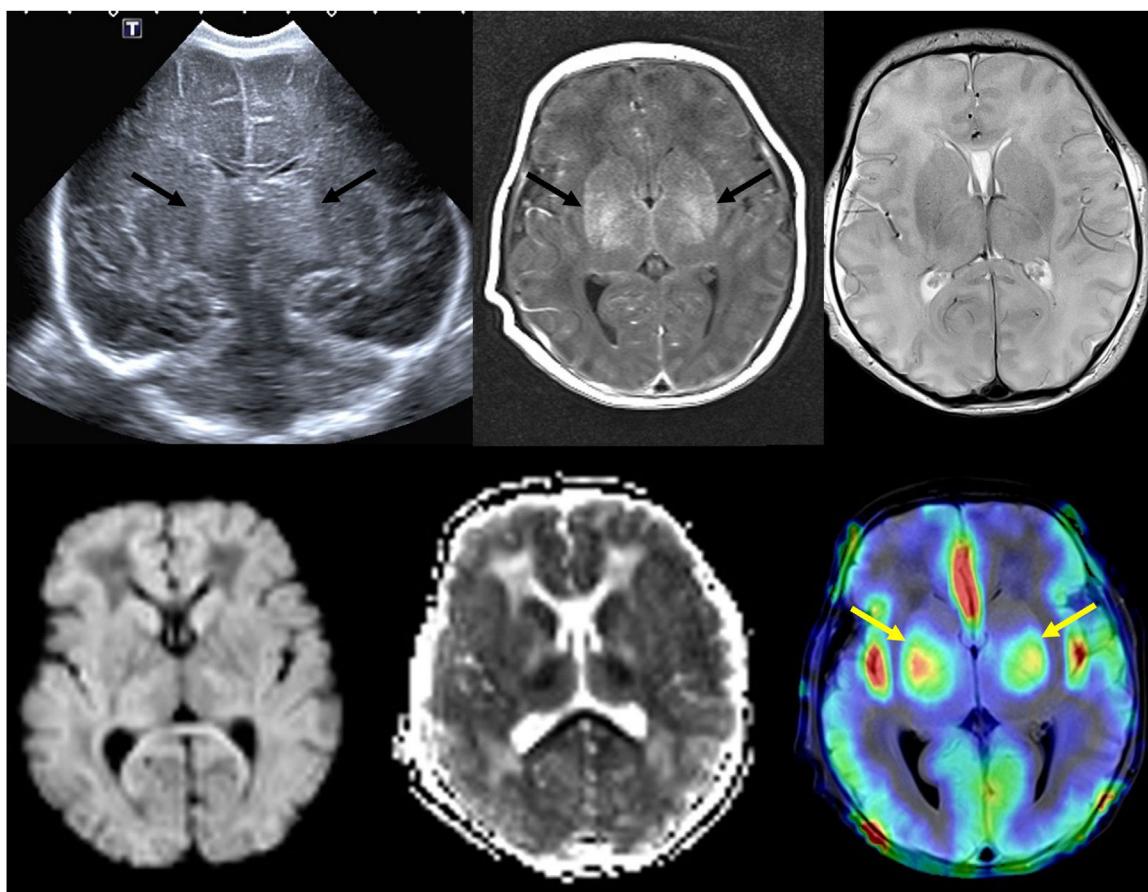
(A) Transfontanellar ultrasound performed on the first day of life in a full-term newborn with severe hypoxia-ischemia showing bilateral central gray matter injury (arrows). (B) Head MRI performed 4 days post birth showing bilateral central gray matter injury in T1- and T2-weighted images, with restricted diffusion and evidence of increased perfusion in arterial spin labeling (arrows), which has been associated with a poor prognosis.
